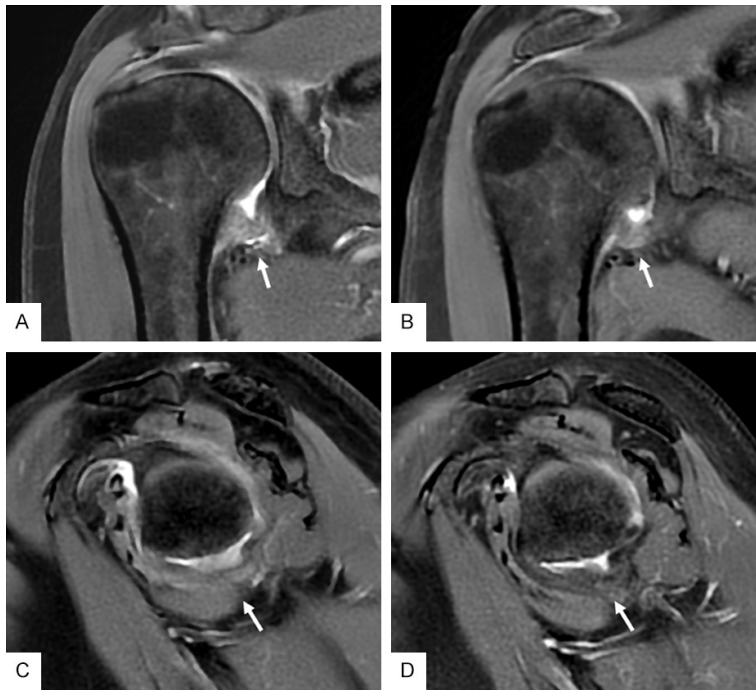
49-year-old woman with FS, severe pain and limited range of motion for more than 4 months. A. Oblique coronal fat-suppressed T2-weighted MR image shows diffuse joint capsule edema of the axillary humerus with thickening of contracture (arrow). B. After 6 weeks of treatment, the edema and thickness of the axillary joint capsule were reduced (arrow). C. Oblique sagittal fat-suppressed T2-weighted MR image shows obvious axillary joint capsule edema (arrow). D. After 6 weeks of treatment, the edema of the joint capsule of the axillary humerus was better than before (arrow).
